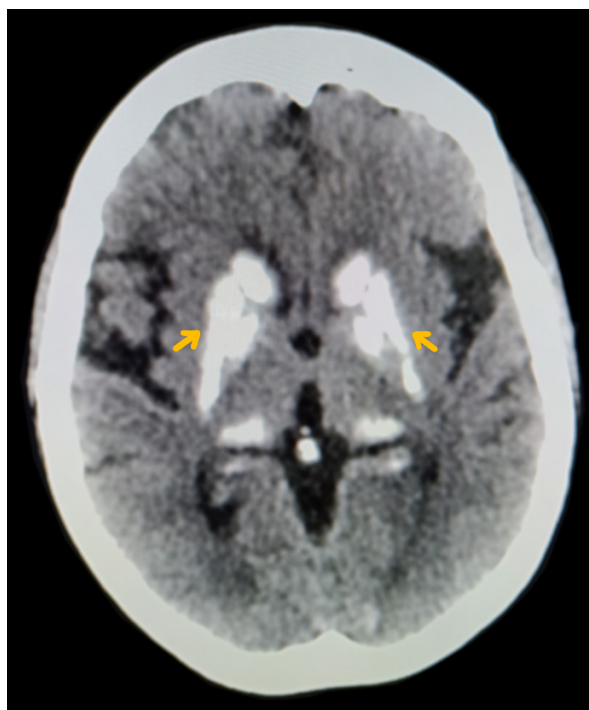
Computed tomography (CT) of the head with arrows pointing to bilateral dense calcifications in the basal ganglia suggestive of Fahr's syndrome
